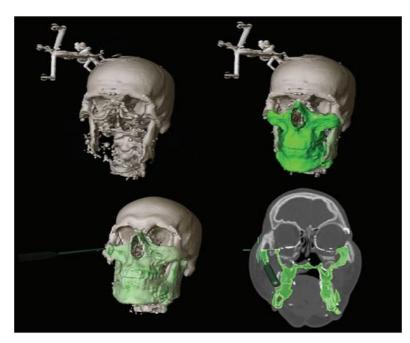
Using intraoperative surgical navigation to confirm the accuracy of the skeletal allograft positioning and comparing between planned (green) and actual position of the skeletal segments. Registering the computed tomographic scanned (above) verifies an accurate skeletal segment position (below) [6].
